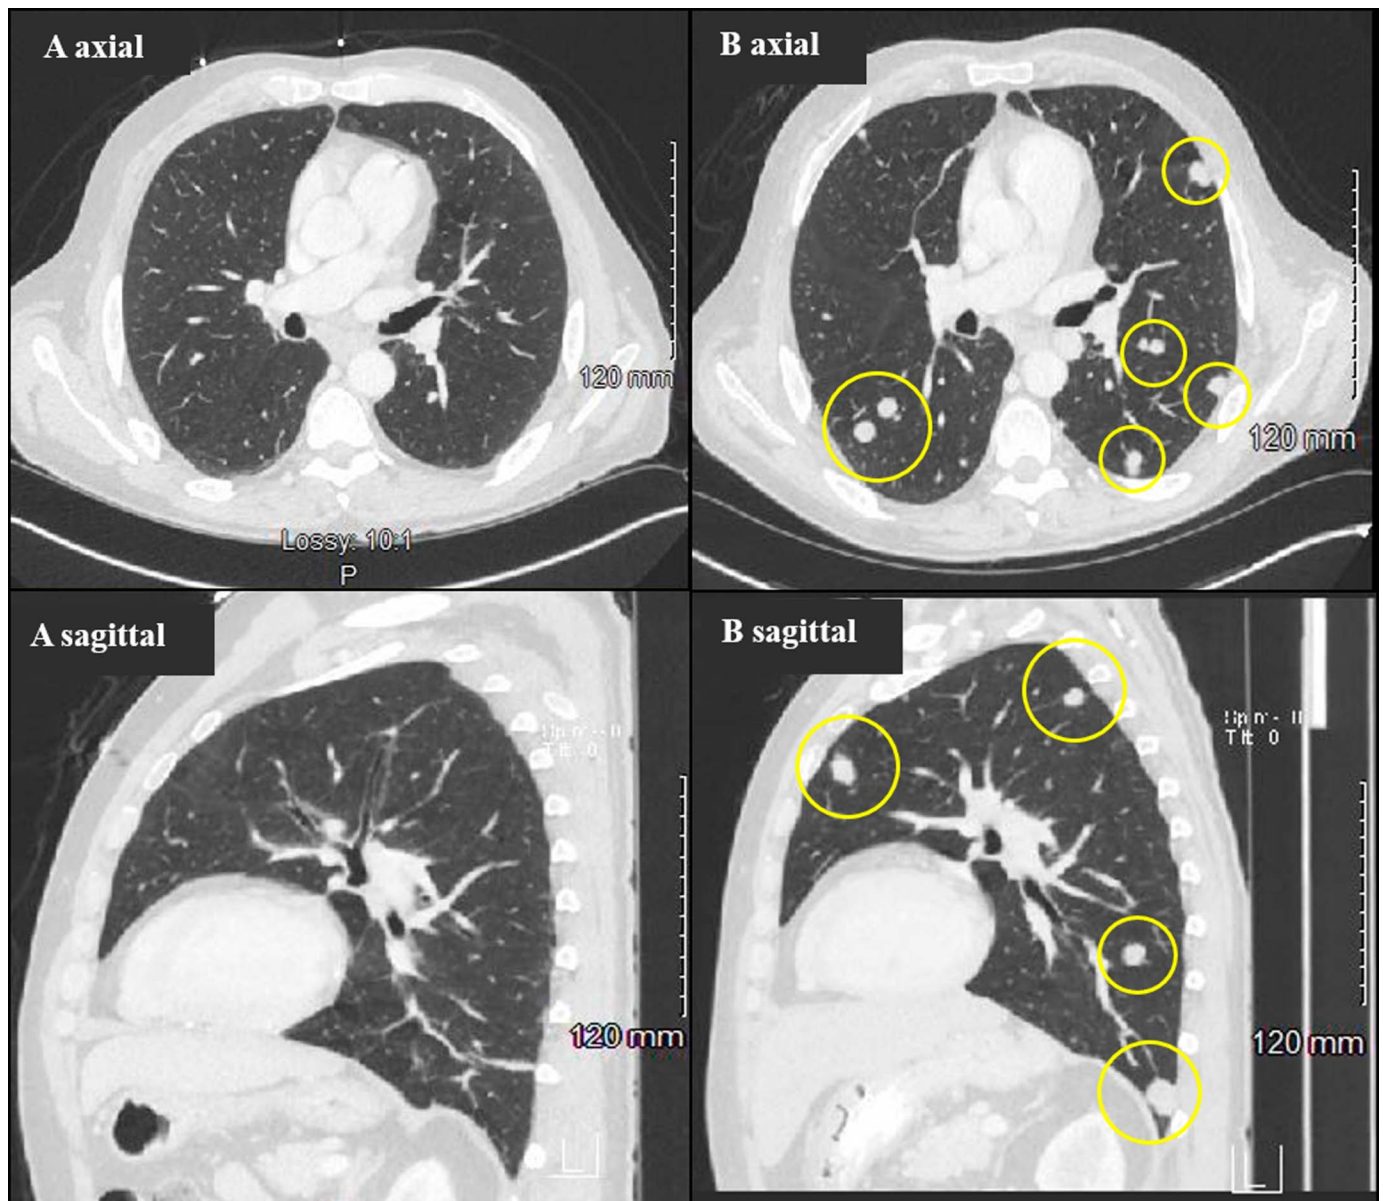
Representative lung window computed tomography images at comparable axial and sagittal planes, (A) before and (B) after transarterial radioembolization showing the development of new multifocal rounded pulmonary metastasis (yellow circles).
